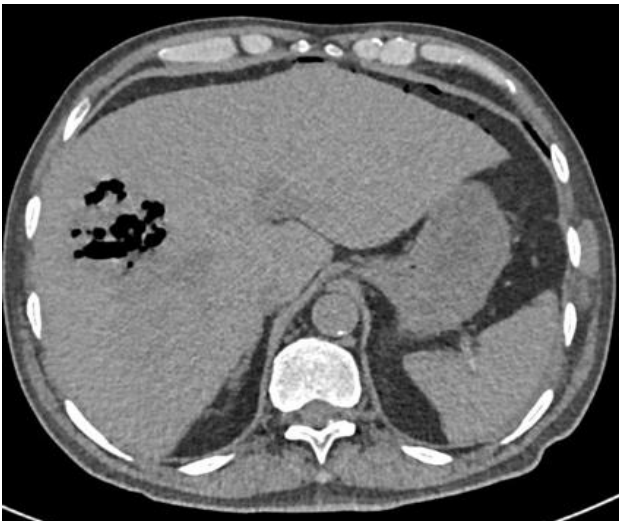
Non-contrast abdominopelvic CT scan (sagittal view).
